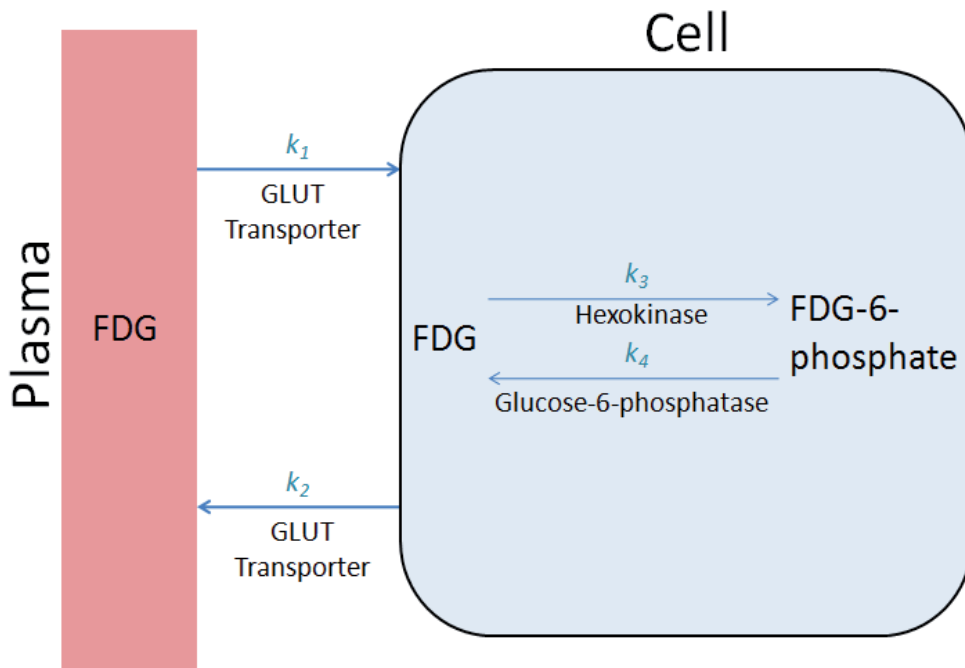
The three-compartment model involves the transport of FDG from the plasma to the cell, as well as the phosphorylation and dephosphorylation of FDG within the cell. Simpler models ignore the dephosphorylation of FDG, thereby eliminating the k_4 rate constant.
